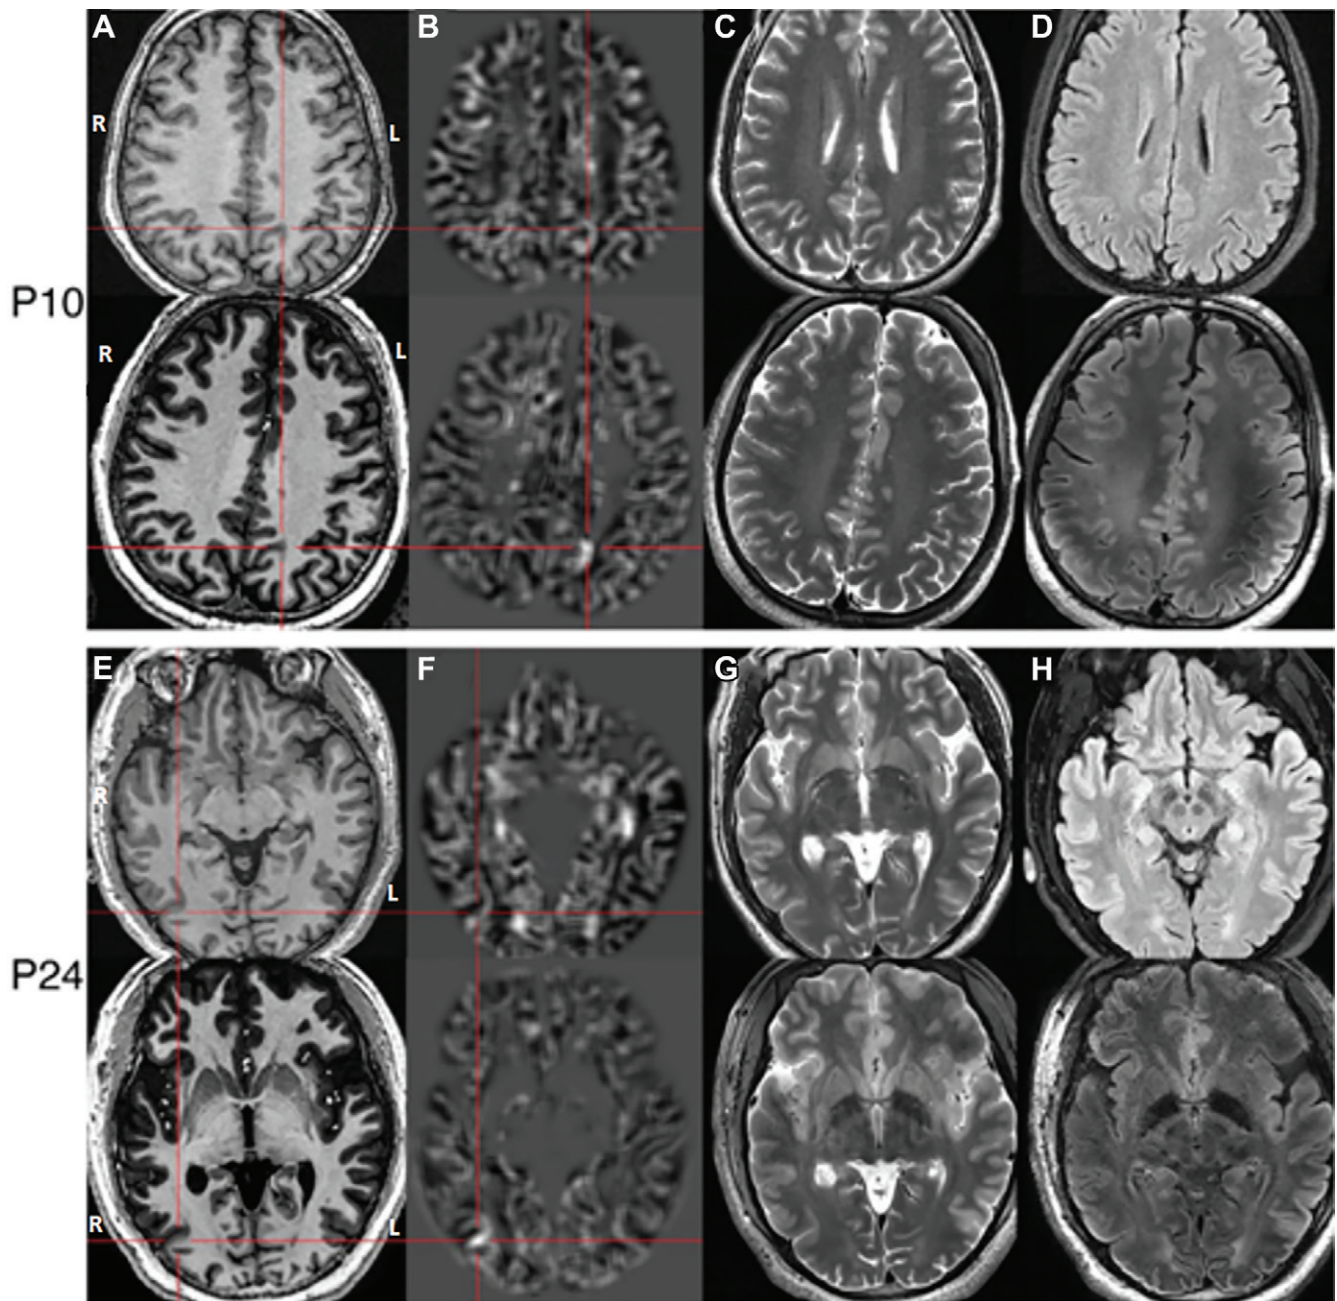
Two focal cortical dysplasia type IIa lesions newly identified at 7-T MRI. For each patient (patient 10 [P10], a 32-year-old man, and patient 24 [P24], a 28-year-old man), the (A) T1-weighted, (B) morphometric analysis program (MAP) junction map, (C) T2-weighted, and (D) fluid-attenuated inversion recovery (FLAIR) images from 3-T (upper rows) and 7-T (lower rows) imaging are shown. Images obtained with 3-T MRI and MAP postprocessing (A, B; upper row) failed to provide clear localizing clues for these two lesions. In contrast, images obtained with 7-T MRI and MAP postprocessing (A, B; lower row) show obvious abnormalities. These two subtle lesions are difficult to identify on T2-weighted or FLAIR images at 3 T and 7 T (C, D). Red lines are crosshairs, and the center point of the red lines indicates the location of the epileptogenic zone. (Adapted, with permission, from reference 84.)
